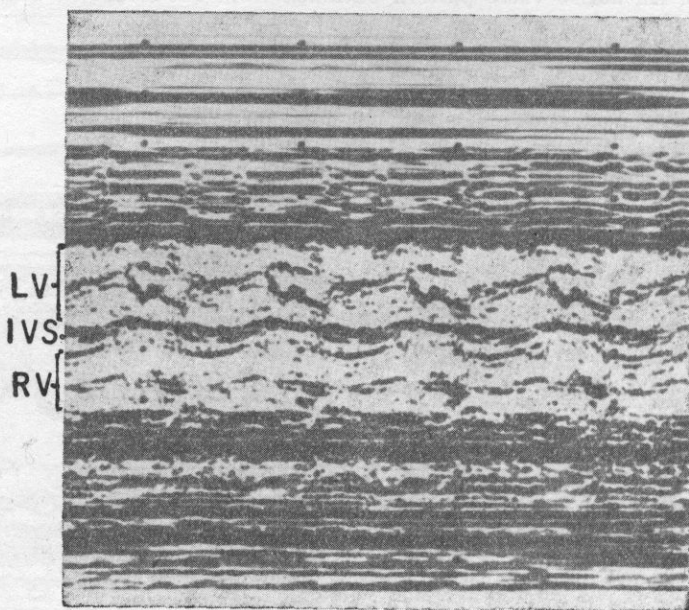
A mitral valve echocardiogram pattern obtained from the image in Fig. 2
